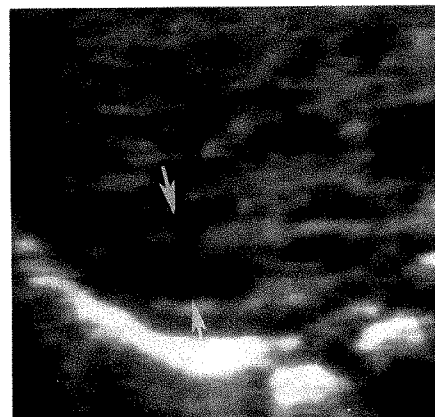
Longitudinal sonogram of a normal left adrenal gland (arrows).
